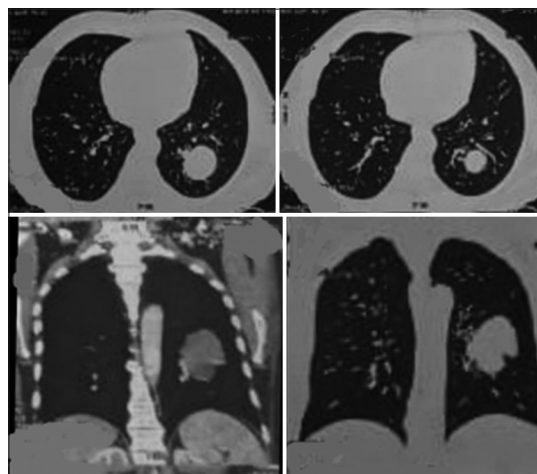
Contrast-enhanced computed tomography chest revealed a well-defined opacity measuring 6.8 cm × 6.0 cm × 6.7 cm in the apical segment of the left lower lobe showing peripheral areas of calcification with minimal enhancement
